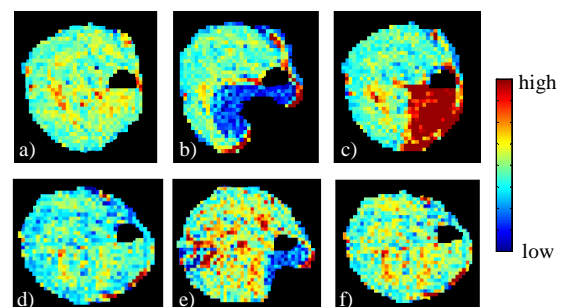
Perfusion index maps taken before (a,d), during (b,e) and 30 minutes after loading (c,f) for resp. large and modest indentation. The perfusion maps with large indentation are obtained in the same experiment as the T2-weighted images in figure 1.
